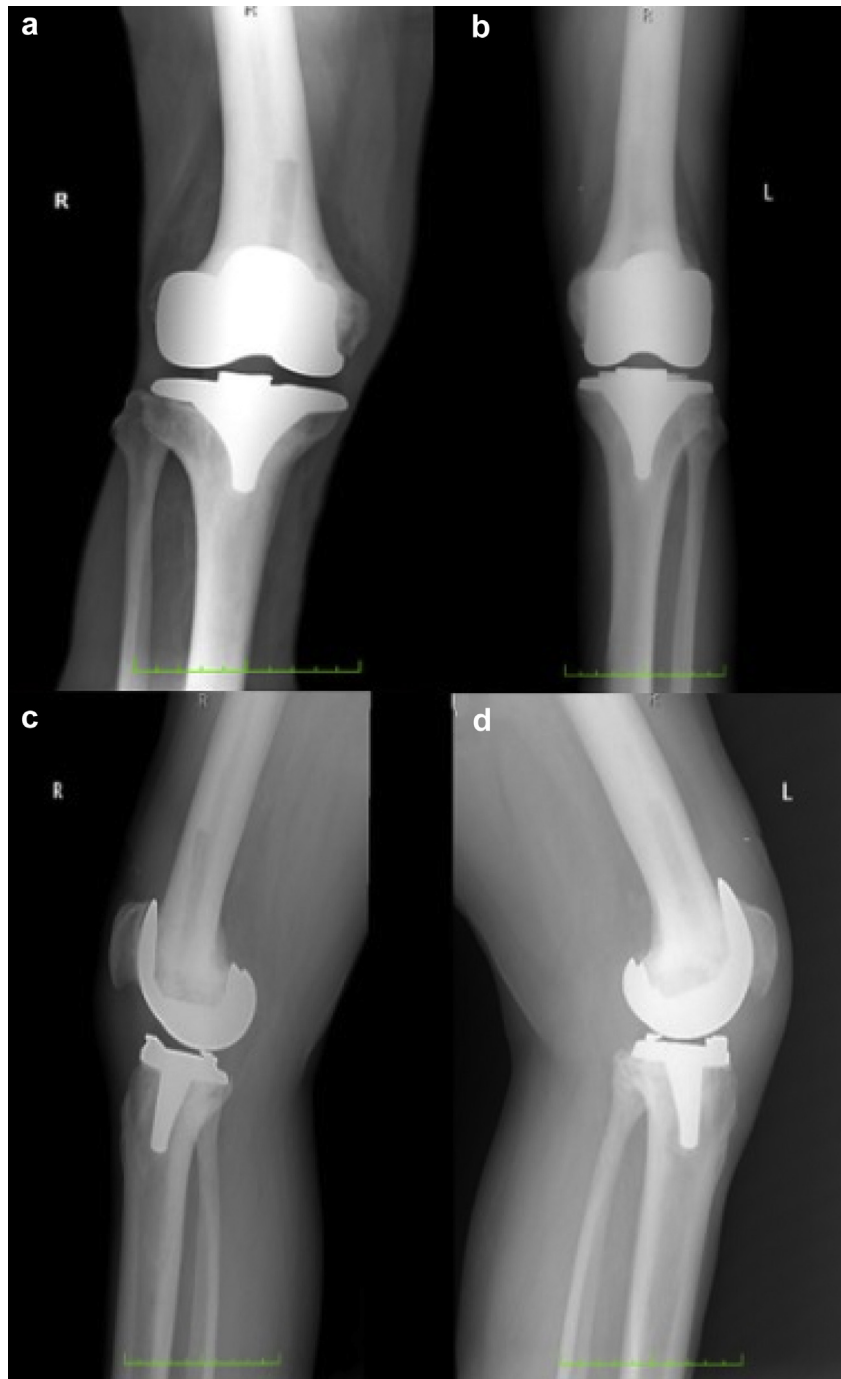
Postoperative bilateral AP (a and b) and lateral (c and d) radiographs revealing proper alignment of implants at 22 months of left TKA (b and d) and at 12 months of right TKA (a and c). AP, anteroposterior.
